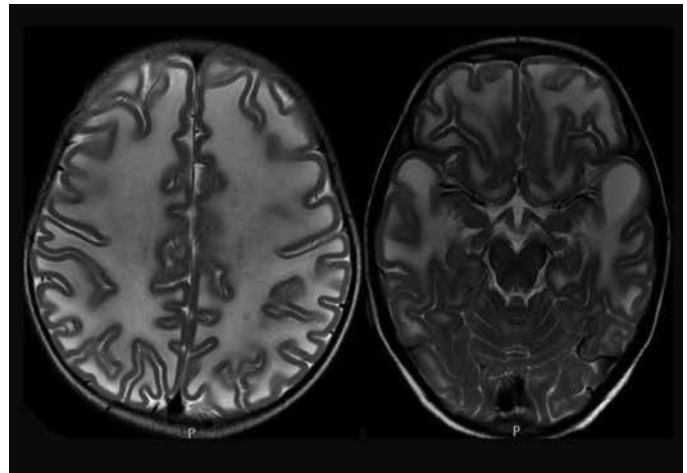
Axial T2-weighted image shows diffuse symmetrical T2 hyper-intense signal change in bilateral cerebral white matter and T2 hyper-intense subcortical cysts in the bilateral anterior temporal lobes
